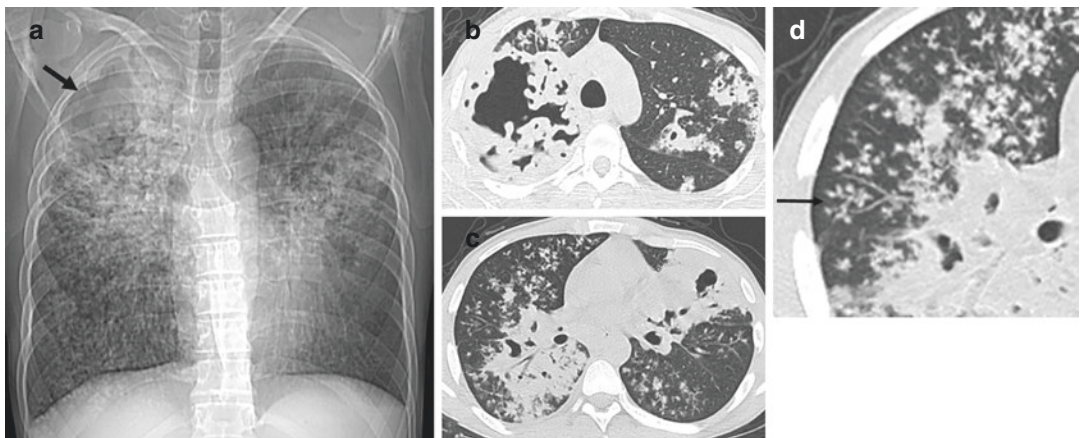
Post-primary tuberculosis in a 35-year-old man. (a) PA chest radiograph shows bilateral alveolar opacities in the upper lungs with a cavity in a right opacity (arrow). (b) and (c) Axial HRCT images show bilateral cavitating consolidation
